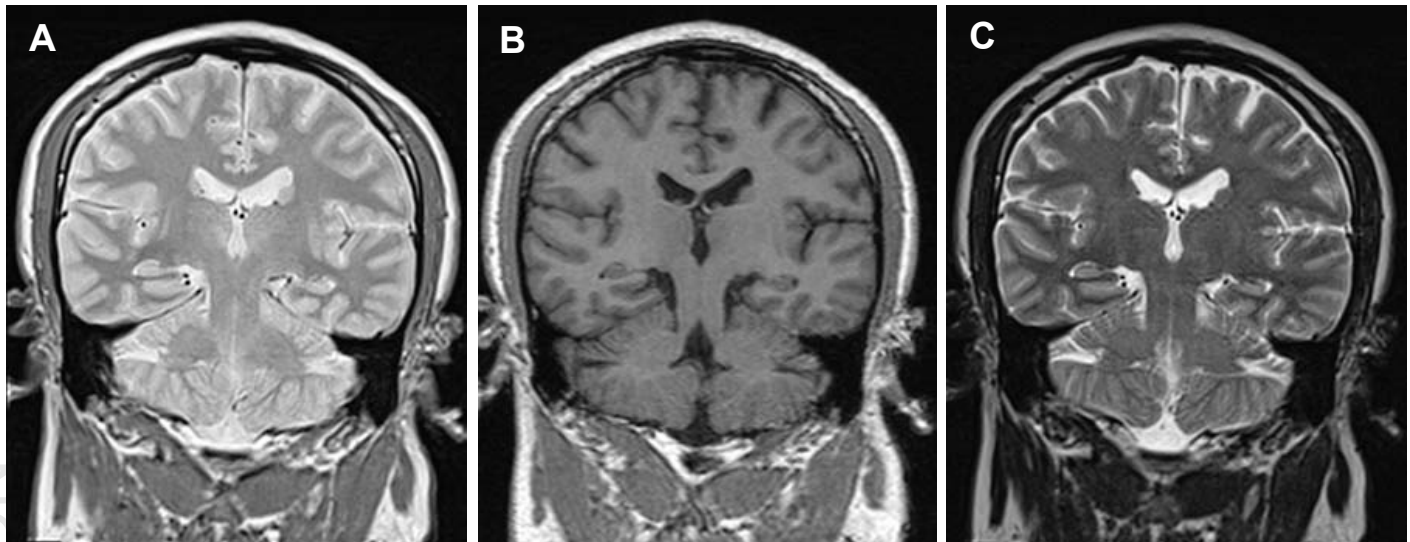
Coronal images of the brain. (A) Proton density-weighted. (B) T1-weighted. (C) T2-weighted. Courtesy of University of Iowa Carver College of Medicine.
